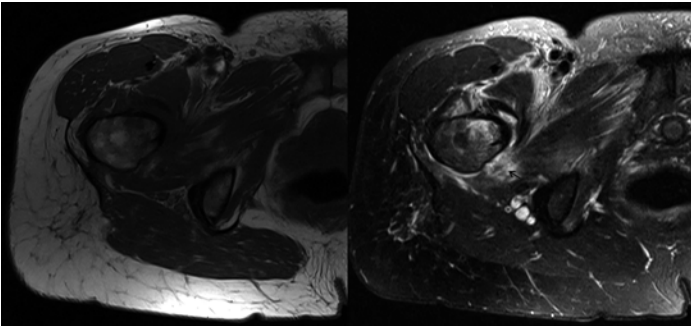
Axial T1- and T2-weighted MR through the pelvis demonstrating significant edema (*black arrow*) and trace fluid within the adductor compartment, consistent with low-grade adductor strain.
